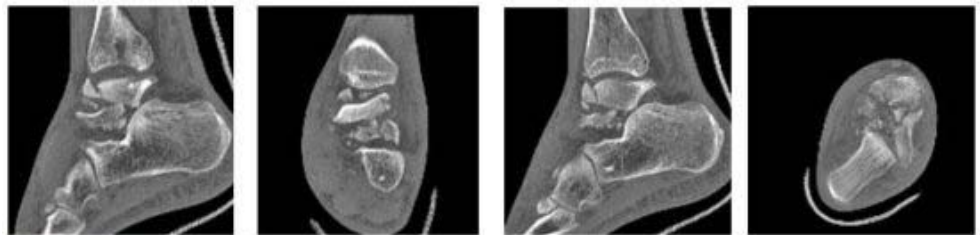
Comminuted talus fracture, preoperative CT.
